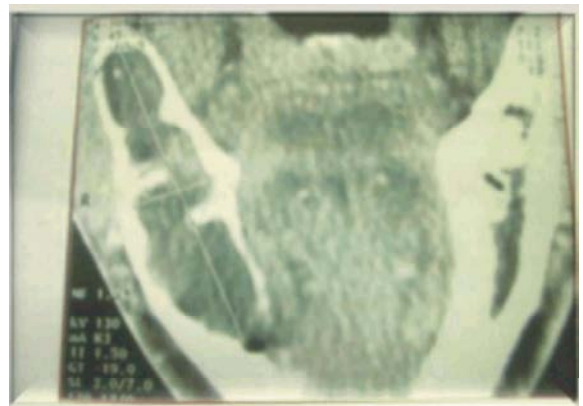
Coronal CT Scan revealing the presence of large cystic cavity involving both the body and ramus of the mandible and measuring 2.7cm length, and 1.8 cm width.
